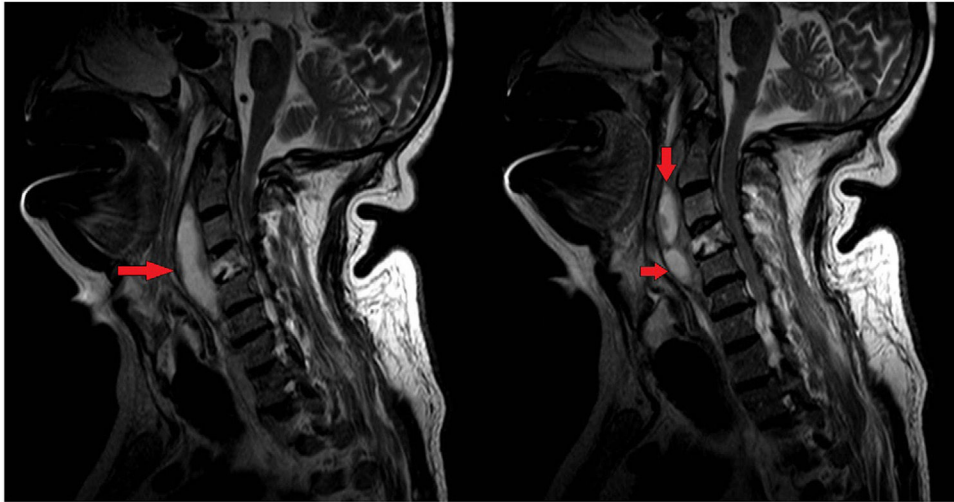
Abscessed collection in the C1–C5 paravertebral space, hyperintense on the T2-weighted sequence, that continues with a different C5–D1 collection (arrows).
